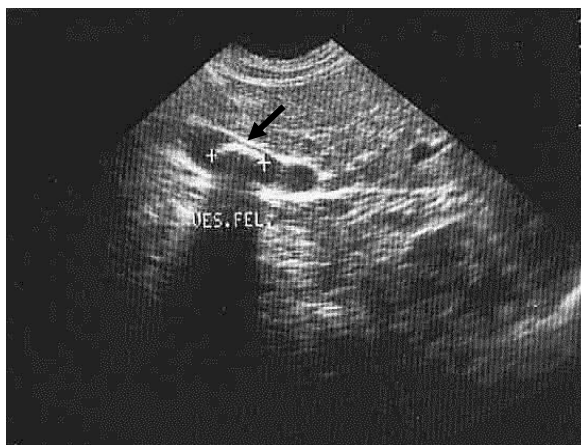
Sonogram of gallbladder. The stone on the sonogram looks as hyperechogenic formation (arrow) with an ultrasonic shade behind it (ultrasonic track).
